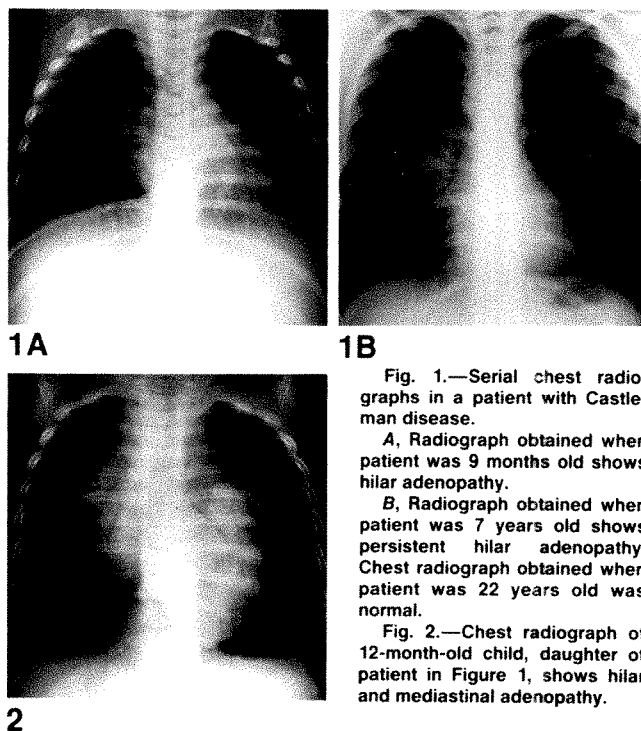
Serial chest radiographs in a patient with Castleman disease.
